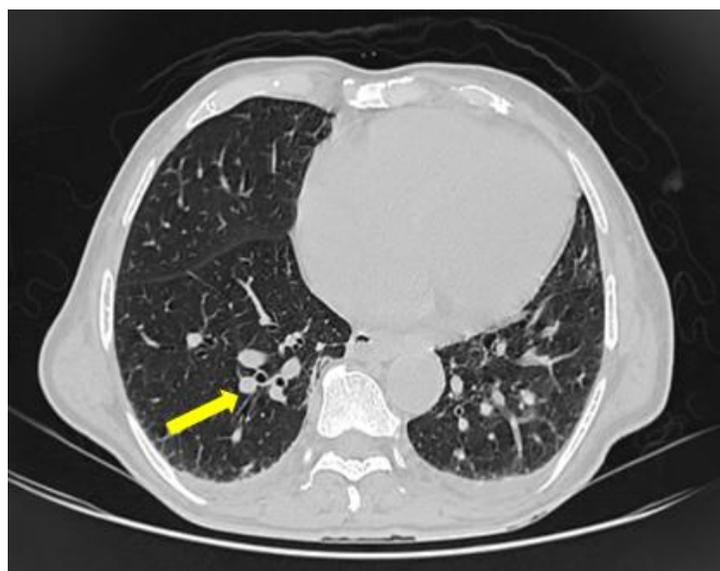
HRCT thorax of Case 1 showing multiple enlarged lymph nodes in the mediastinal, axillary and cervical regions, with a yellow arrow indicating the mediastinal lymph nodes.
